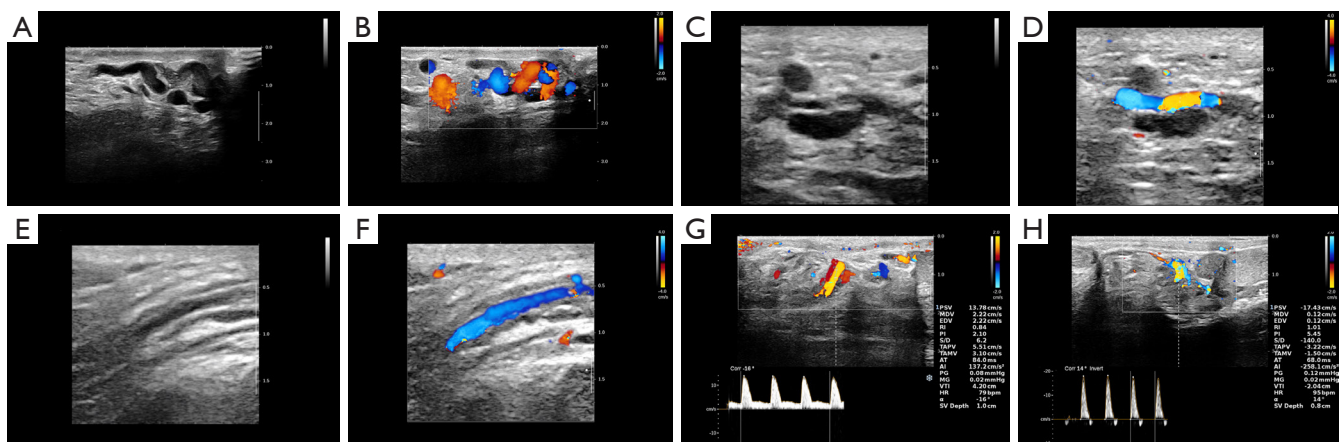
Ultrasound images for the detection of the testicular artery and spermatic vein. (A) Gray-scale ultrasound image of the spermatic vein. (B) Color Doppler flow image of the spermatic vein. (C) Gray-scale ultrasound image of the left testicular artery. (D) Color Doppler flow image of the left testicular artery. (E) Gray-scale ultrasound image of the right testicular artery. (F) Color Doppler flow image of the right testicular artery. (G) Ultrasound blood flow parameters of the testicular artery with a normal spectrum. (H) Ultrasound blood flow parameters indicating abnormality in the testicular artery. PSV, peak systolic velocity; MDV, mean diastolic velocity; EDV, end diastolic velocity; RI, resistance index; PI, pulsatility index; S/D, peak systolic velocity/end diastolic velocity; TAPV, time-averaged peak velocity; TAMV, time averaged mean velocity; AT, acceleration time; AI, augmentation index; PG, peak gradient; MG, mean gradient; VTI, velocity time integral; HR, heart rate; SV depth, maximum valley depth.
